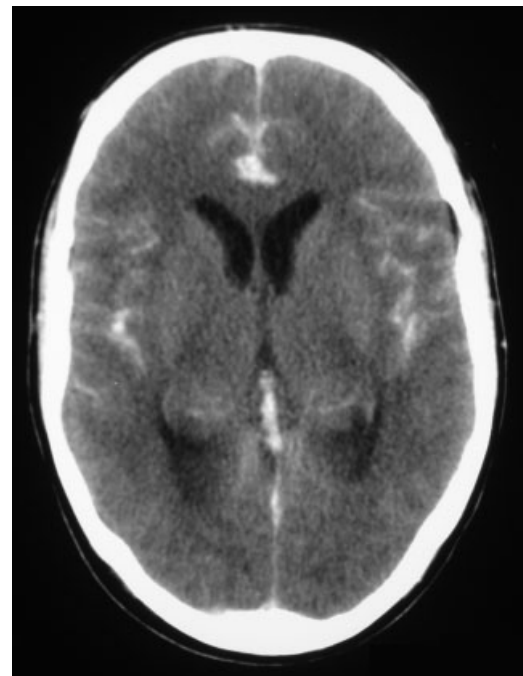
A cranial CT shows a diffuse subarachnoid hemorrhage, with a small clot in the interhemispheric fissure.
